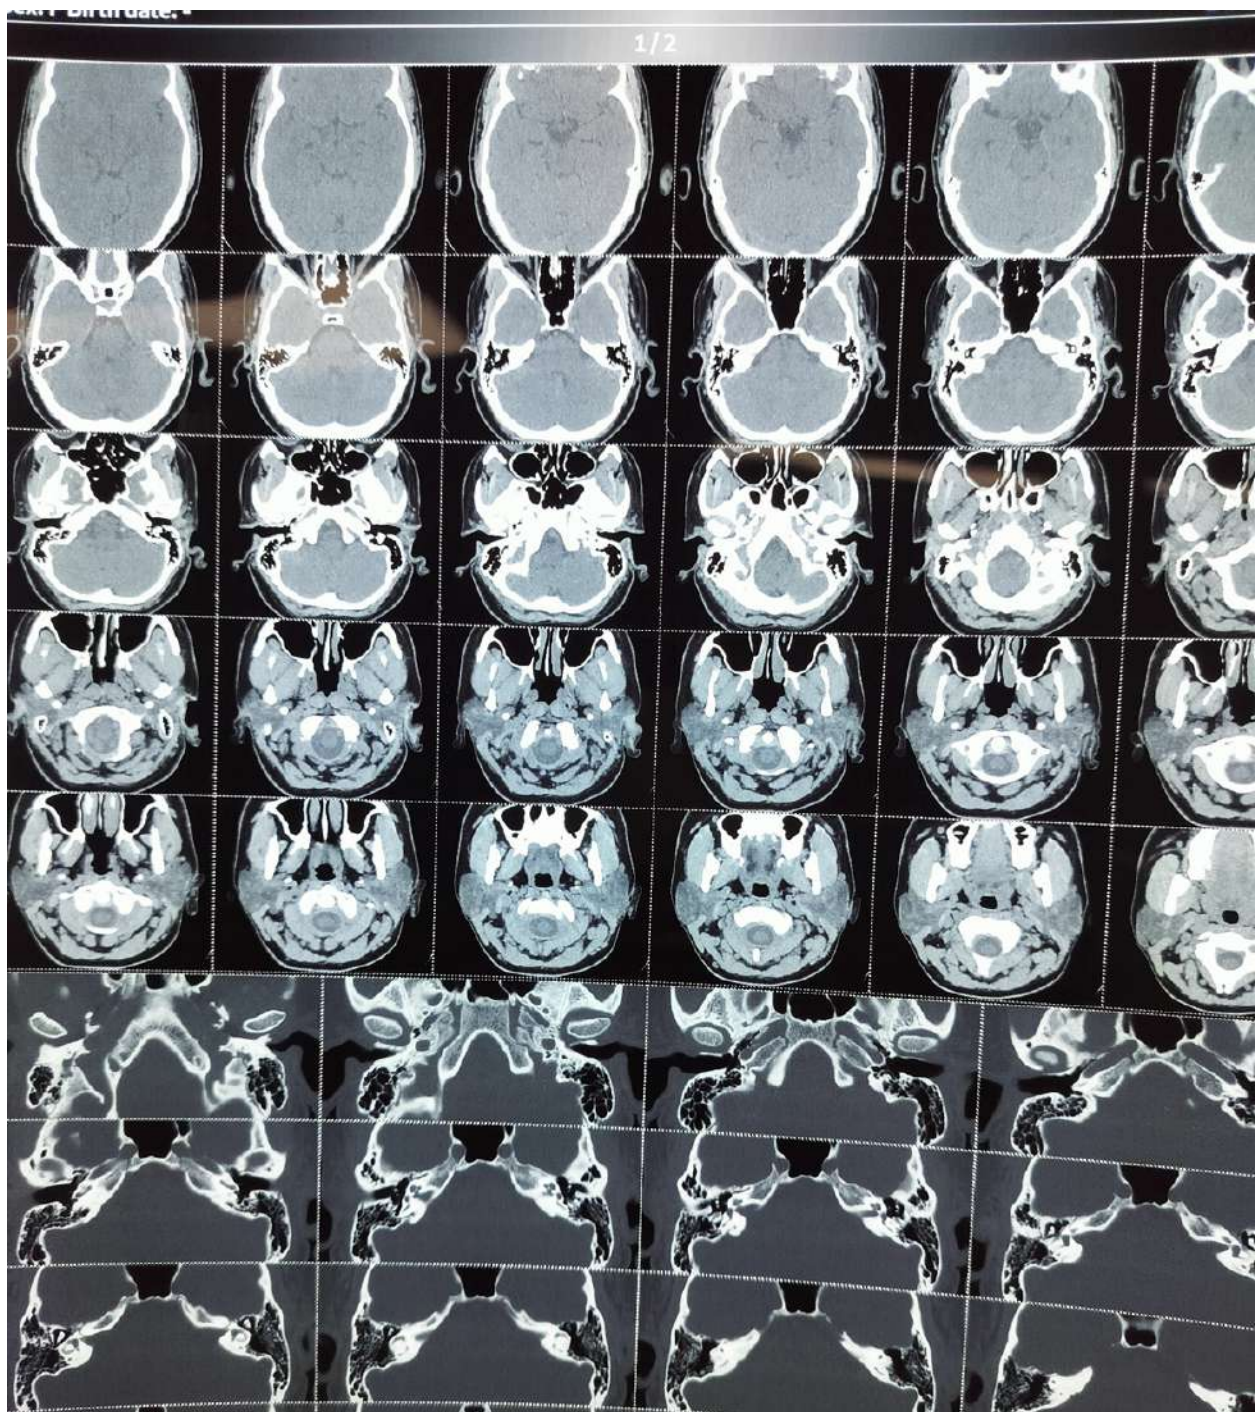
Contrast Enhanced CT of Head and Neck Showing Contrast Enhancement in the Left Pinna
